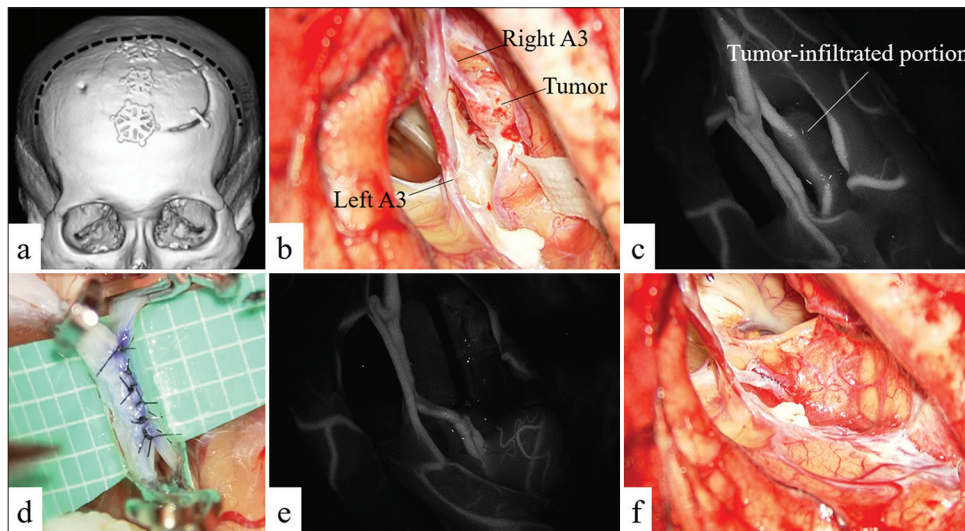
(a) Preoperative CT scan showing frontal craniotomy (previous bicoronal skin incision is shown as a dotted line). (b) Intraoperative photograph showing the right A3(Rt A3) is infiltrated by the tumor. (c) Indocyanine green (ICG) videography showing the tumor infiltrating a portion of A3. (d) Intraoperative photograph showing that an A3–A3 side-to-side anastomosis has been performed. (e) ICG videography showed the patency of the bypass. (f) Intraoperative photograph showing the tumor has been completely resected.
